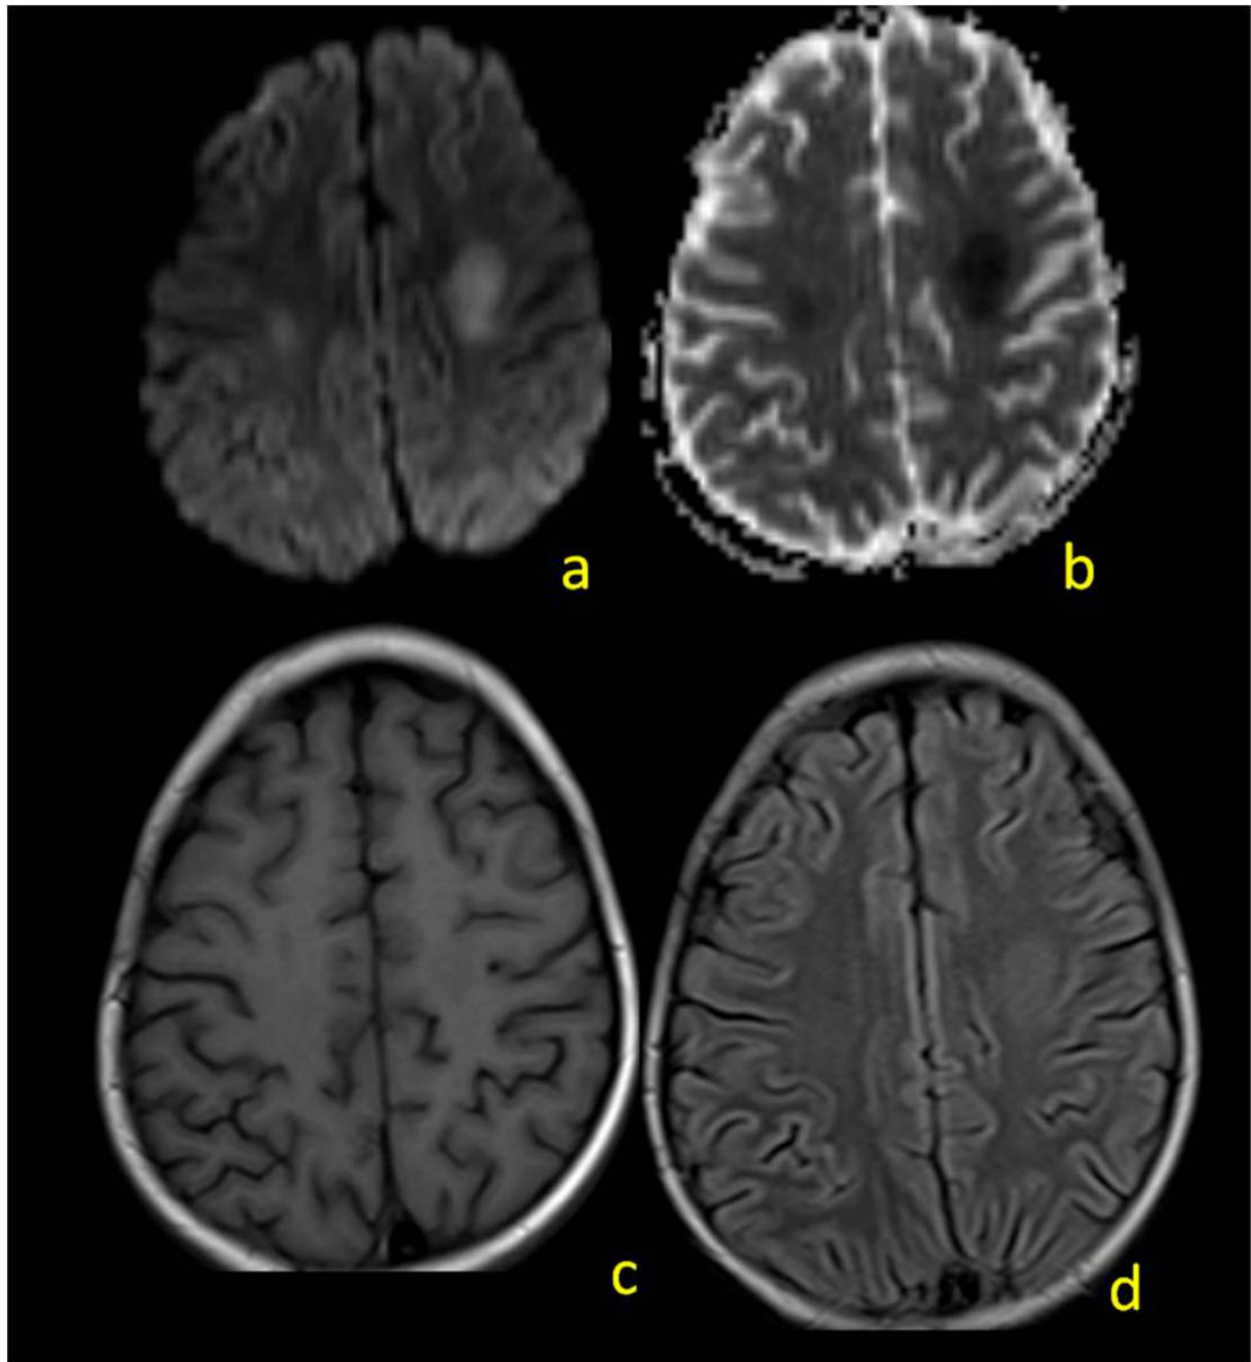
12 years old female patient with AML presented with altered mental status , initial MRI showed bilateral asymmetrical areas of restricted diffusion in the Centrum semiovale , more evident in the left side. These areas shows dark signal reduced ADC
